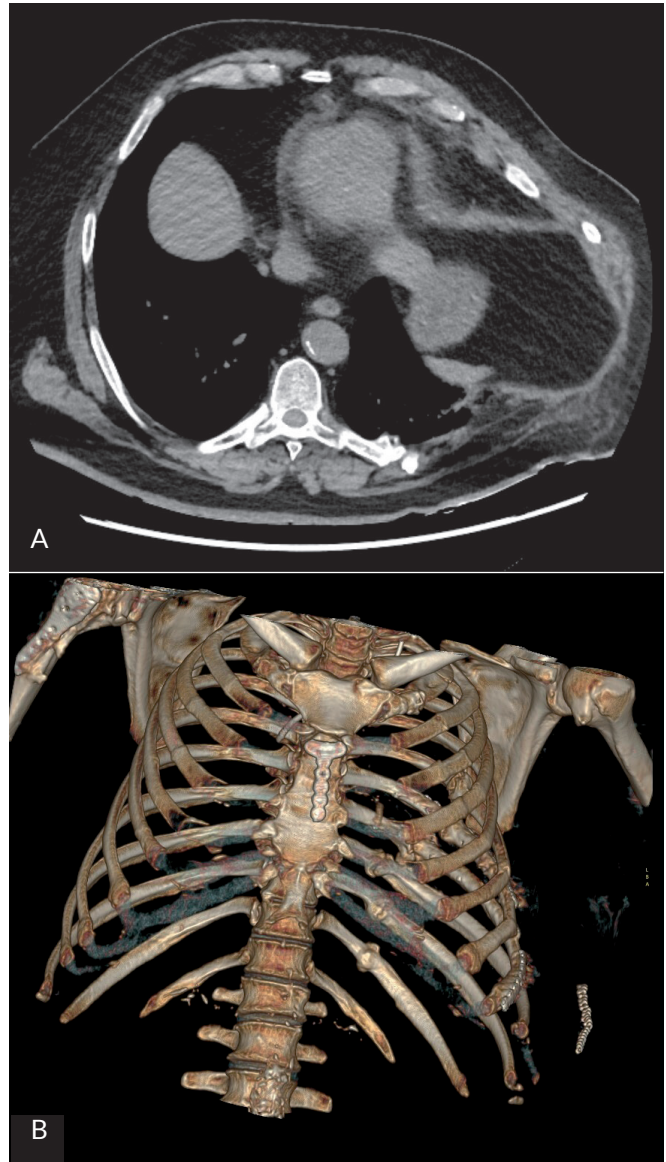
Case 4. Computed tomography findings. A. preoperatively. B. postoperatively
